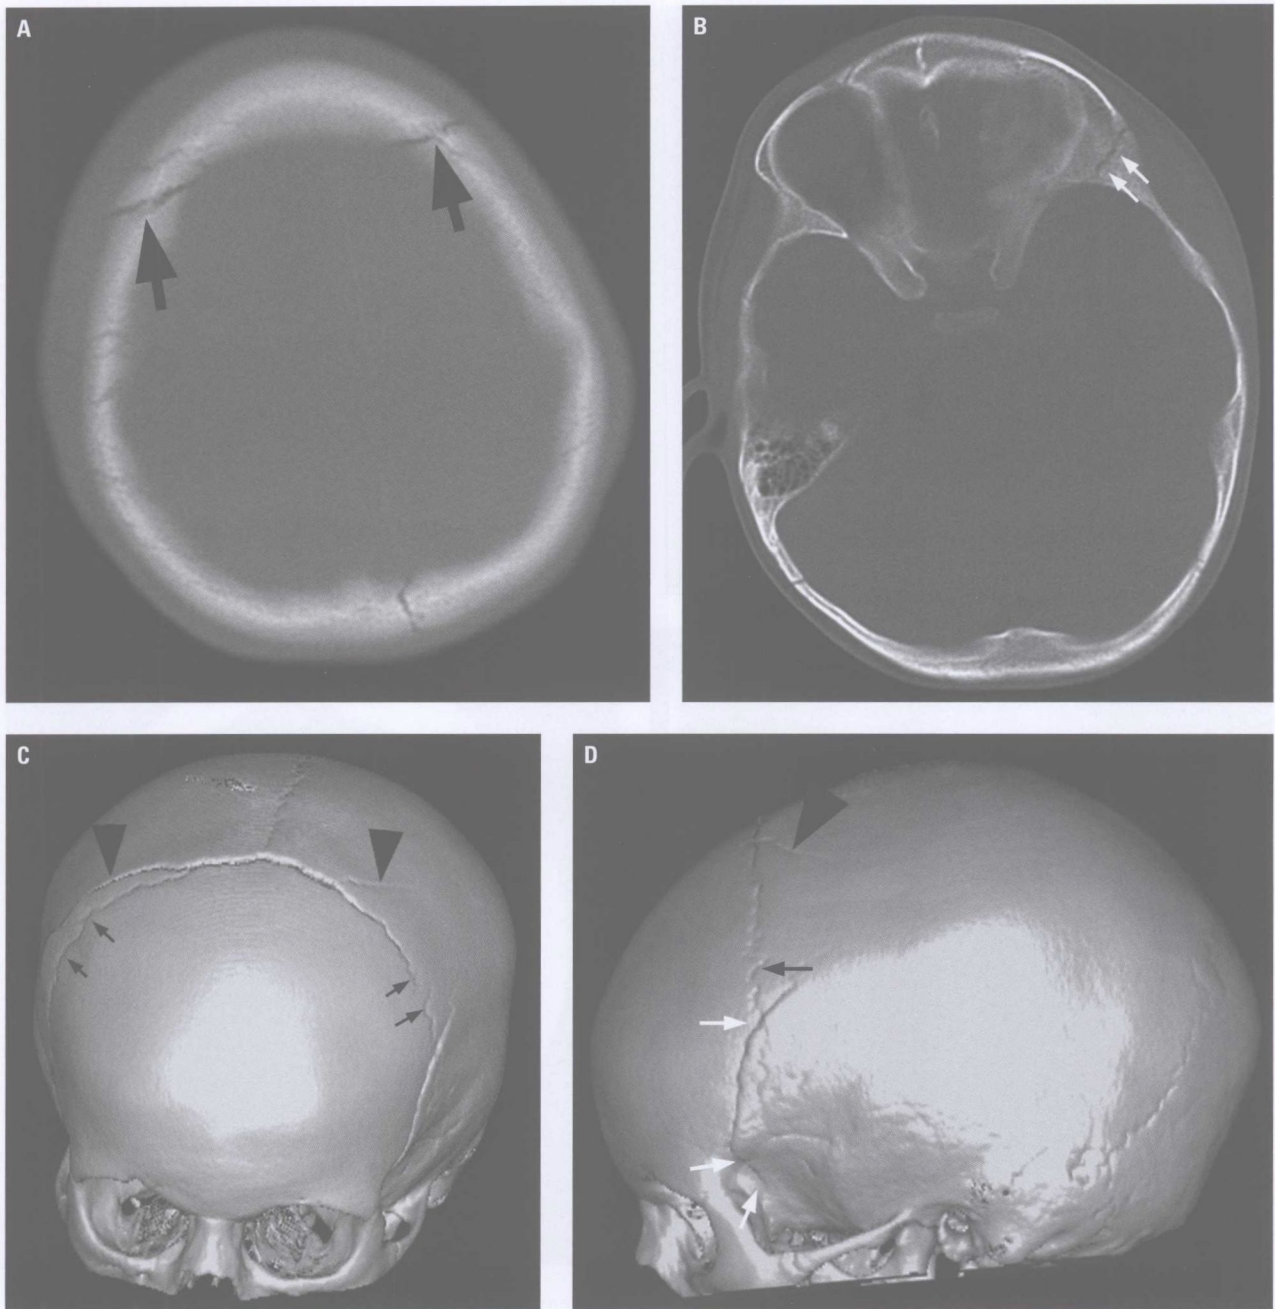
On axial CT (A) of a 3-year-old boy who fell 12 feet out of a window, bilateral parietal fractures (*black arrows*) could easily be mistaken for the coronal suture. Fracture extension into the sphenoid bone (*small white arrows*) is subtle on axial CT images (B). 3D surface renderings of the calvarium (C) easily allow differentiation of bilateral parietal fractures (*black arrowheads*) from the coronal suture (*small black arrows*). Lateral 3D surface rendering (D) shows fracture extension across the coronal (*small black arrow*) and frontosphenoid suture into the greater wing of the left sphenoid bone (*small white arrows*). Left high-parietal linear skull fracture is again shown (*black arrowhead*).
